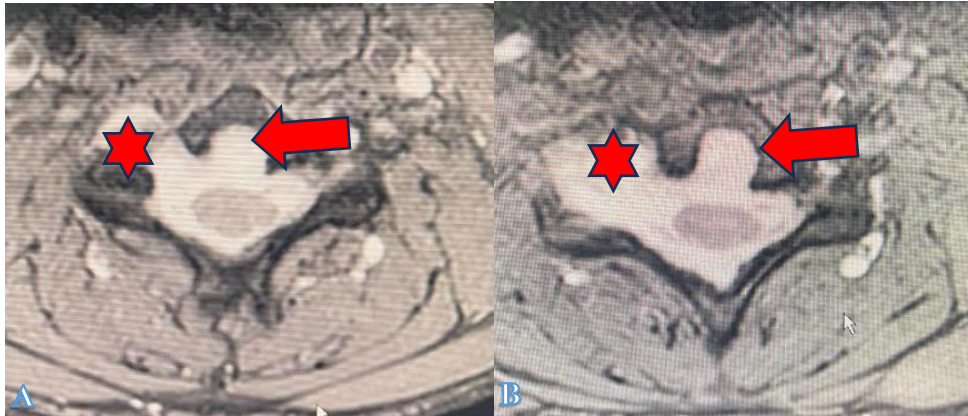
A, B): Axial T2 MRI; posterior vertebral bone scalloping of C5, C6, C7 (arrows) and left meningoceles at C5-C6 and C6-C7 (*).
